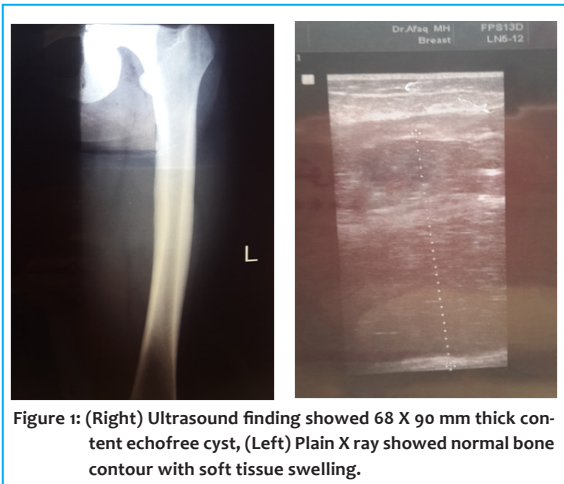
(Right) Ultrasound finding showed 68 X 90 mm thick content echofree cyst, (Left) Plain X ray showed normal bone contour with soft tissue swelling.
